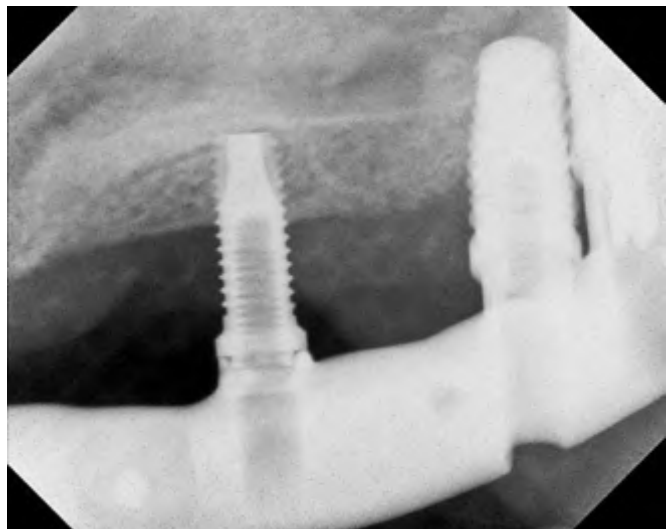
Radiographic image that demonstrated a passive fit of the maxillary framework. The abutment screw was in place in the second implant (right to left). The framework was noted to fit without a radiolucency visible between the framework and the implant restorative platform of the right distal implant.
